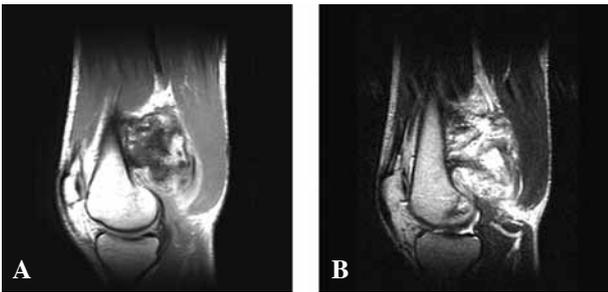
Magnetic resonance imaging revealed a mass on the posterior cortex of the distal femur. A) The periphery of the lesion showed a hardly defined edge and a heterogenous enhancement of the mass periphery on T1-weighted images after contrast administration. B) On T2-weighted images the mass turned out to be heterogenous and displayed a markedly increased signal. The mass displaced the popliteal vessels posteriorly.
